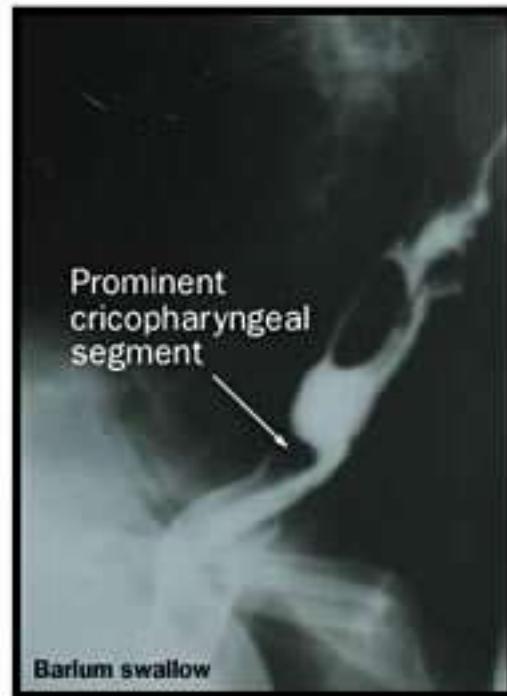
Radiographic image of cricopharyngeal dysfunction.
